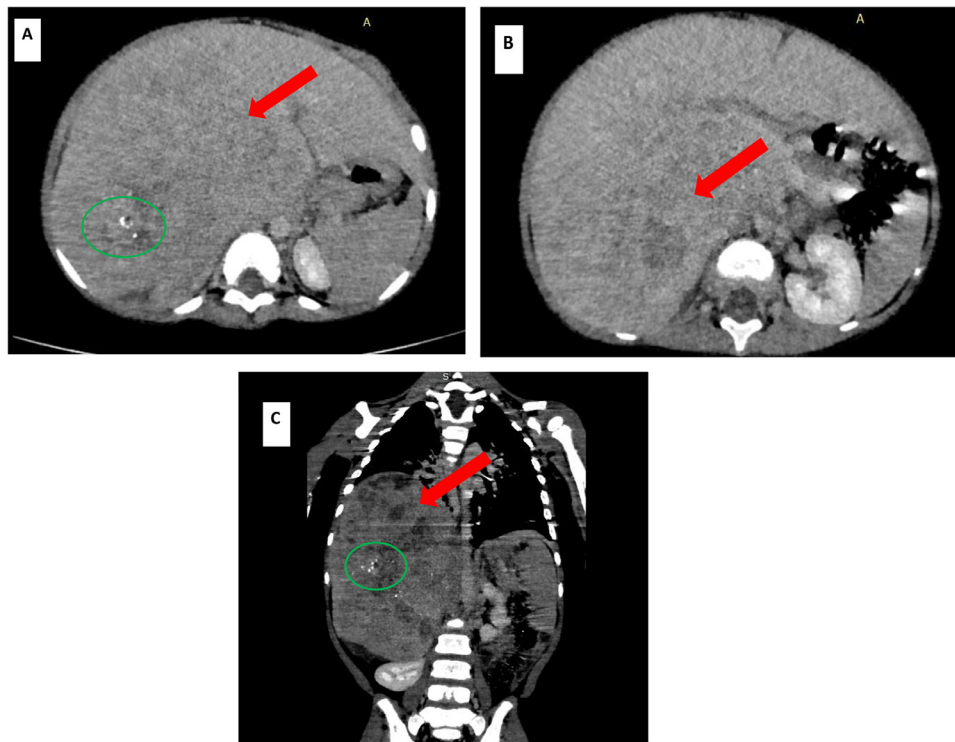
Axial (A and B) and coronal (C) enhanced CT scan demonstrate a large hepatic mass (red arrow), roughly rounded with polylobed contours, heterogeneous, containing calcifications (red circle) and liquid areas, showing moderate enhancement after injection of contrast agent.
